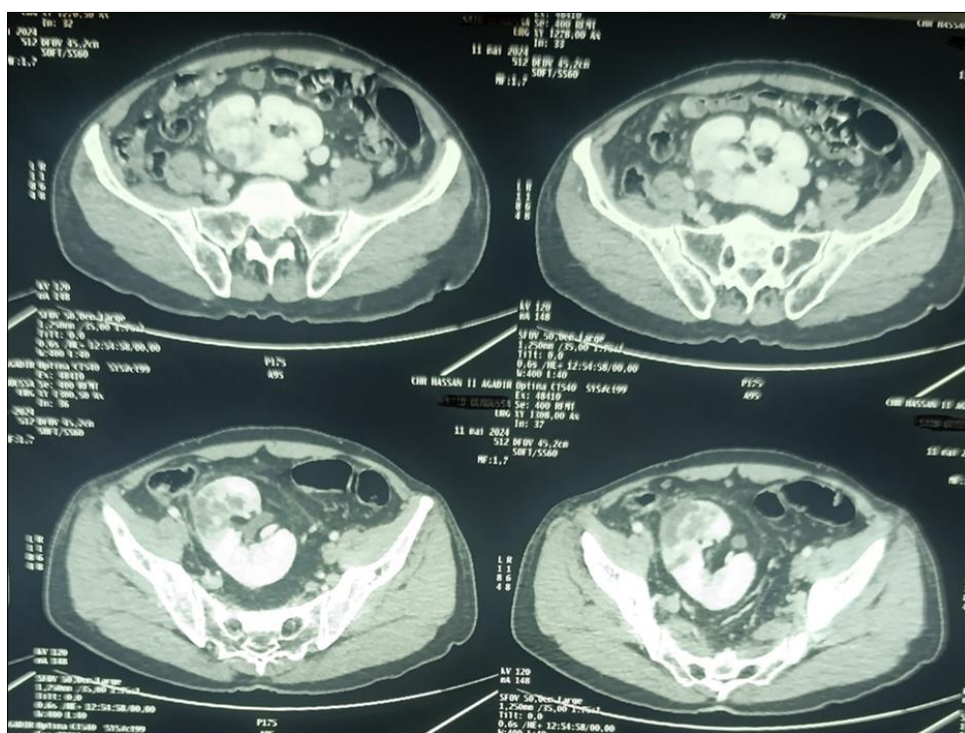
CT image of the abdomen showing a single ectopic kidney in the pelvic position with a hypodense area suggesting acute pyelonephritis
